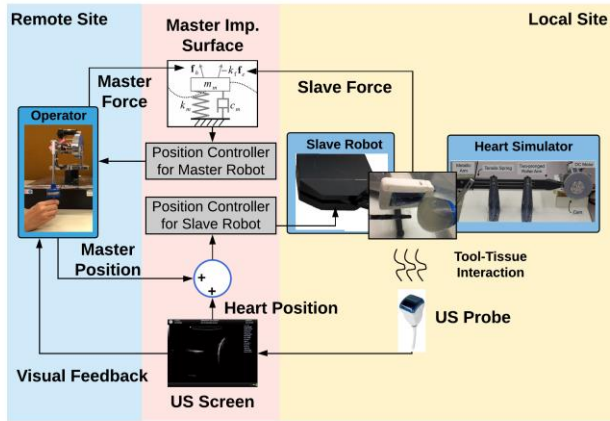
System concept of the proposal. The reference impedance model for the master robot is proposed to provide the human operator with non-oscillatory haptic feedback, and ultrasound imaging is used to obtain the beating heart's position and control the slave robot to synchronize its motion with the fast heart motion.
